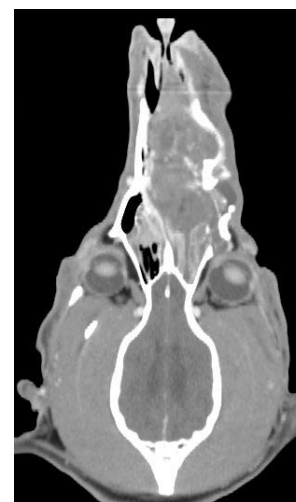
Coronal CT image at the lower zygomatic level revealed the soft tissue mass extended from the cranial nasal passage through the caudal sinonasal area. The mass invaded into the left retrobulbar area.
